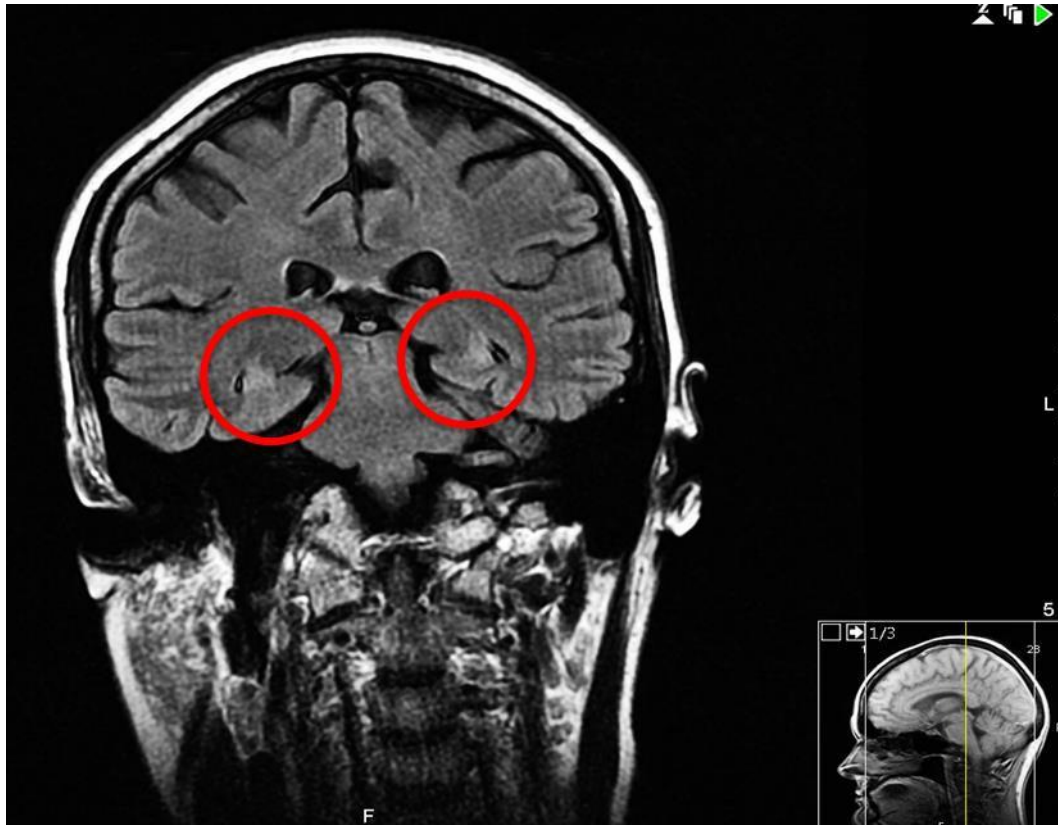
MRI scan of BG (2008) depicting bilateral hippocampal atrophy
